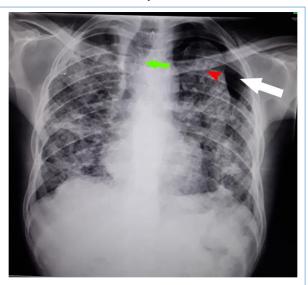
A chest x-ray of the patient showed a collapsed left lung with irregular opacities and a fine reticular pattern of the lung fields (red arrow), left pneumothorax (white arrow) and tracheal deviation to the right (green arrow).
